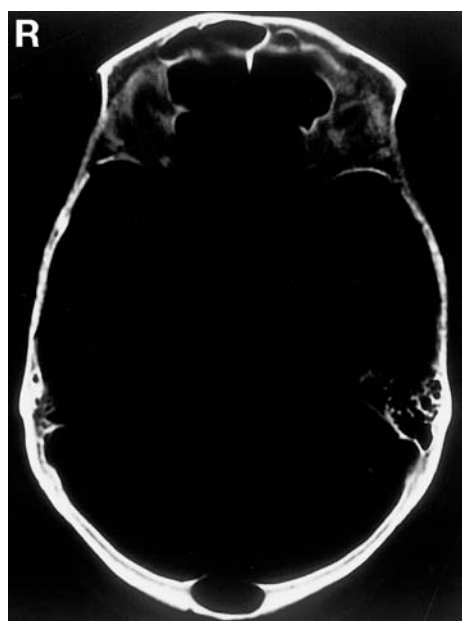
Bone image computed tomography scan showing the widened diploic space and thinning of the inner and outer tables of the occipital bone, and a bony defect of the inner table in the lesion.
